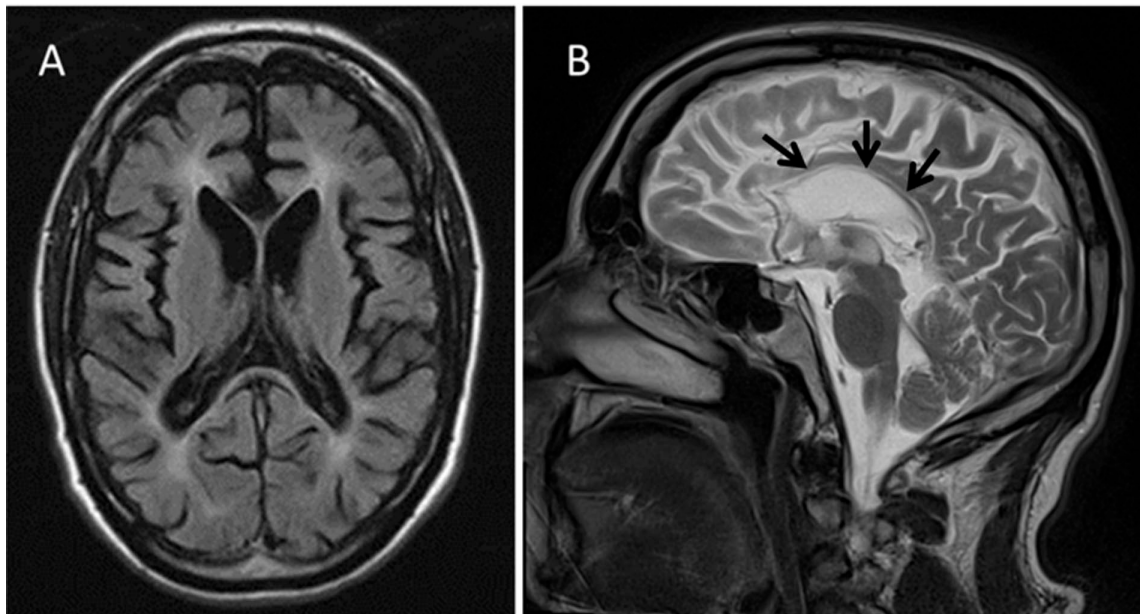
T1 Axial (A) and T2 sagittal (B) MRI in P19. The MRI shows global cerebral atrophy with marked atrophy of the corpus callosum (arrows) (adapted from Pyle *et al.*, 2014).
